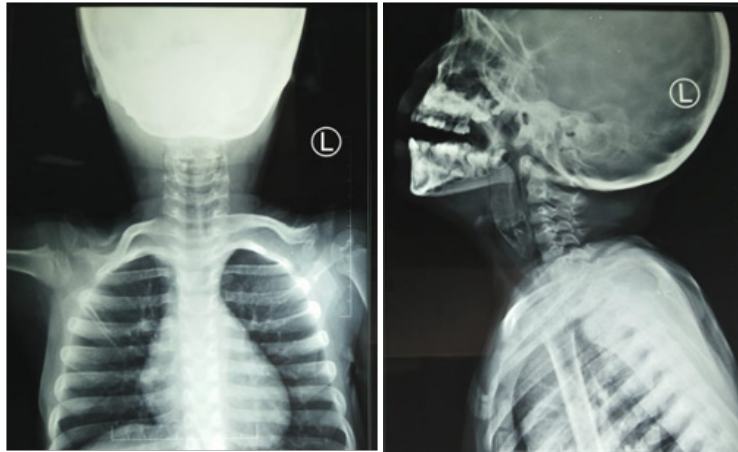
Anteroposterior and lateral cervical x-ray
